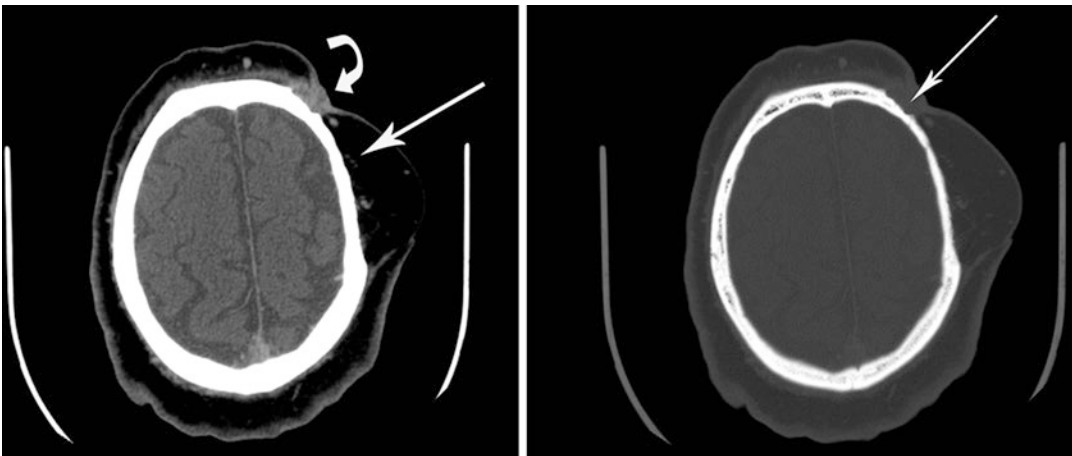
Left:* Axial post-contrast CT image at the level of the recurrence demonstrates an enhancing soft tissue mass (*curved arrow*) at the anterior margin of the flap
